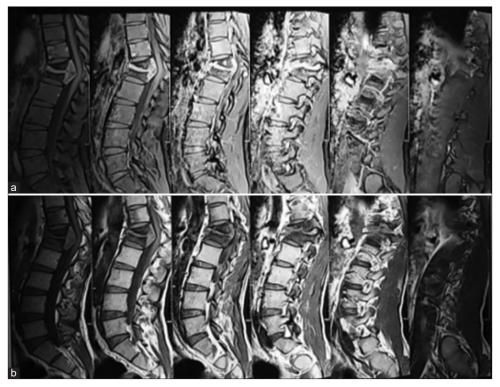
(a-b) Thoracolumbar MRI in a 22-year-old male with spinal TB. T1-weighted image showed isointense mass which inhomogeneously enhanced with contrast administration at level T12-L1. T2-weighted image showed hyperintense mass at T12-L1, destruction of vertebral body, and intervertebral disc, paraspinal and retro-spinal abscess, and pathological fracture at T12 and L1.
